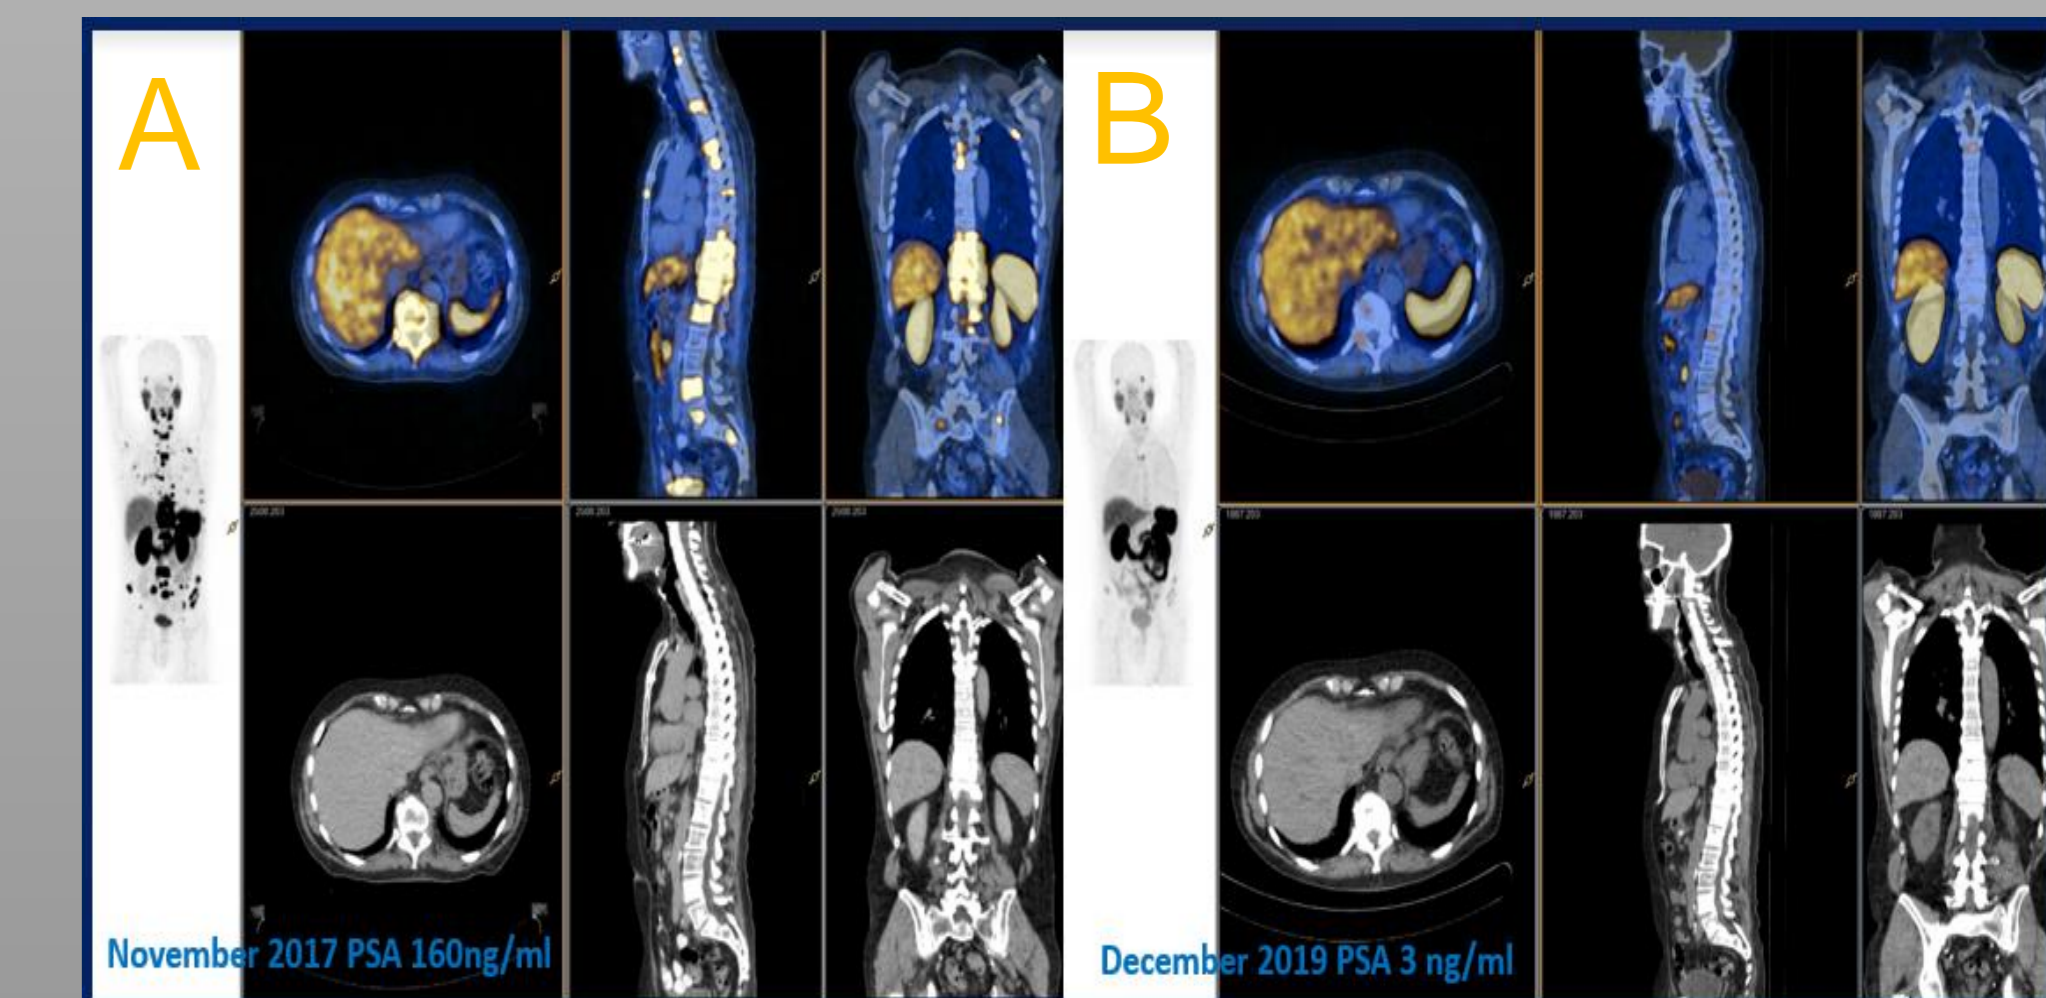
A 76 year old male was enrolled with progressive symptomatic bone metastases post abiraterone and both docetaxel and cabazitaxel. Scan (A) is the prescreening PSMA PET scan and scan (B) the 6 week post treatment PSMA PET. No PSA progression documented to date with no subsequent prostate treatments administered. PSA 3 ng/mL.
